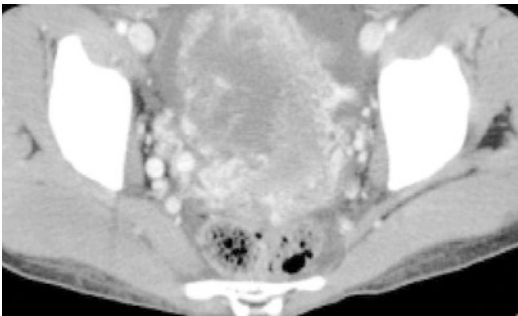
Axial CT image of invasive choriocarcinoma extended to parametrium. (PC: Dr. Pavel Barmon)
